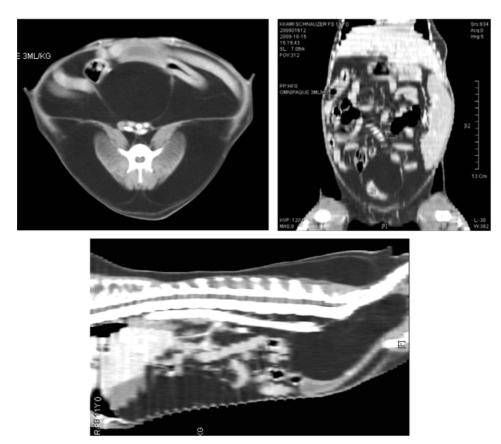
The axial (A), reformatted dorsal (B), and sagittal abdominal CT images. A fatty mass with homogeneous attenuation is identified from 5th lumbar to pelvic cavity. The mass does not show contrast enhancement and evidence of invasion into the surrounding structures.
